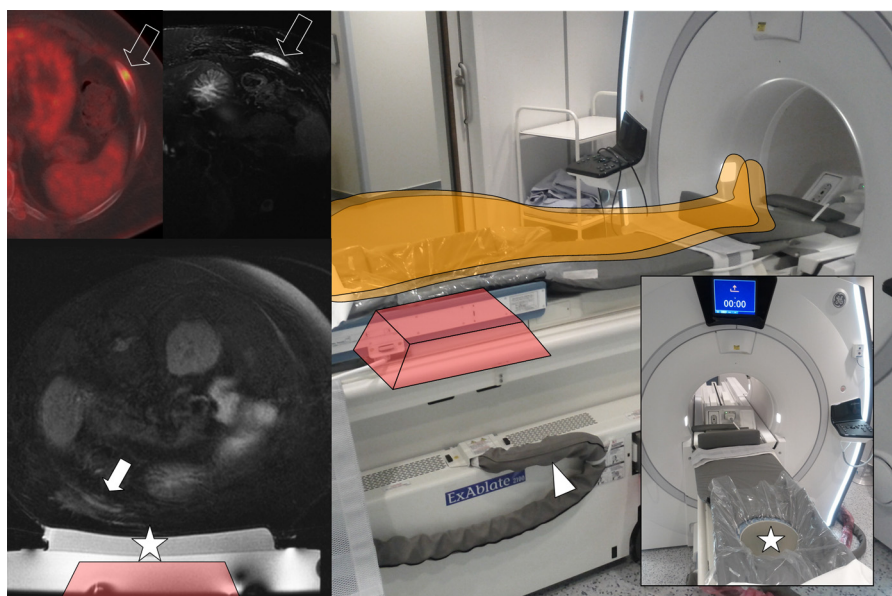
Painful rib metastasis treated by MRgFUS, hardware device and patient positioning. A 54-year-old patient with lung cancer has left thoracic pain (numerical scale = 6/10). A whole body PET-CT has been performed and showed a left rib lesion. Before treatment, an axial T2-weighted MR is performed to be sure that the targeted rib lesion is visible (empty arrow). During the treatment, a local anaesthesia performed on the periosteum (hypersignal T2) allows pain control (plain arrow). As the transducer (red prism) is inside the MRI table, the patient has to be installed in ventral decubitus position to expose the target toward the ultrasound beam. The skin must be directly in contact with the gel pad and the water bath (star) to avoid air interface (risk of skin burn). The system needs a cooler system connected to a water source (plain arrowhead).
